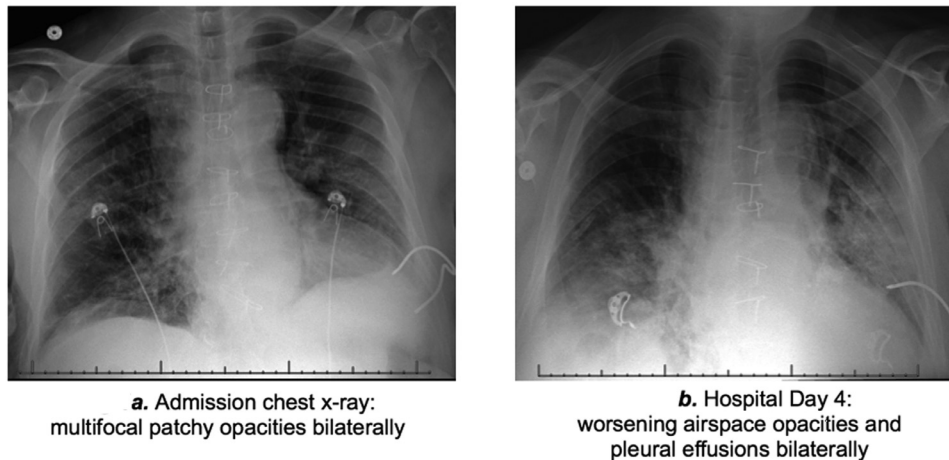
Radiographic assessment of the patient. (a) Admission chest X-ray showing bilateral multifocal patchy opacities. (b) Chest X-ray on hospital Day 4 showing bilateral worsening airspace opacities and pleural effusions.
